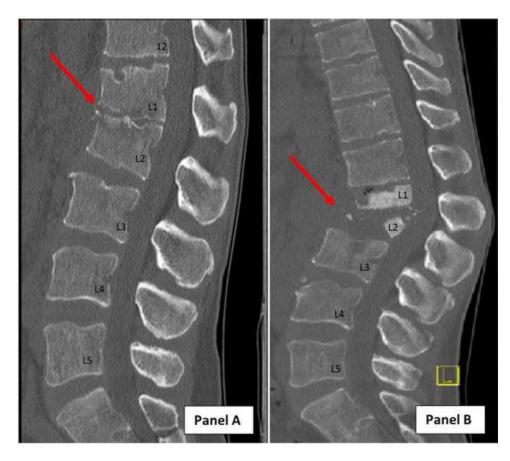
CT scan of the thoracolumbar spine. CT scan demonstrates progression of osteomyelitis and progressive Gibbous deformity of the spine in 3 mo after first presentation - August 2020 (Panel A) and 1 year after first presentation - March 2021 (Panel B).
